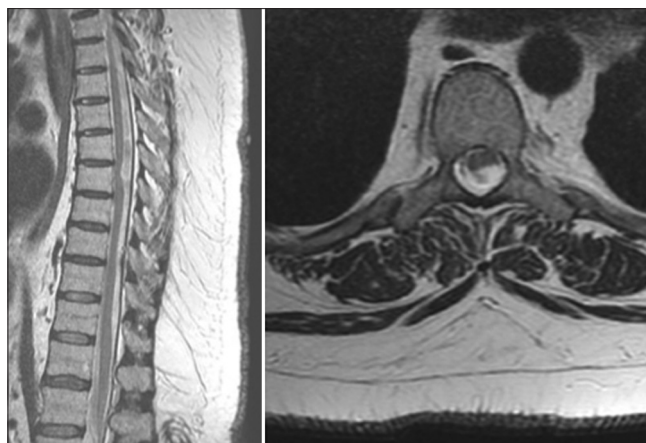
MRI T2-weighted sagittal and axial images. Anterior deviation and flattening spinal cord at T7, small ventral dural defect, mild cord herniation
